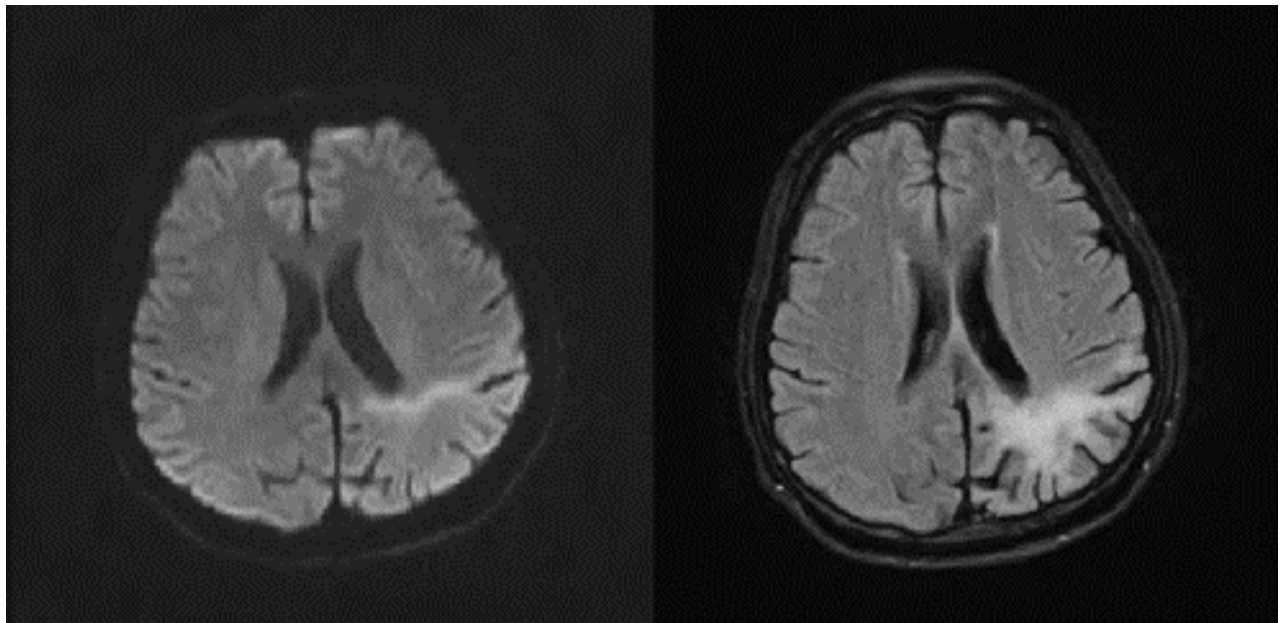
MRI reveals a hyperintense signal in the left parieto-occipital lobes on diffusion-weighted imaging (left) and T2-weighted/ fluid attenuated inversion recovery (FLAIR) imaging (right).
